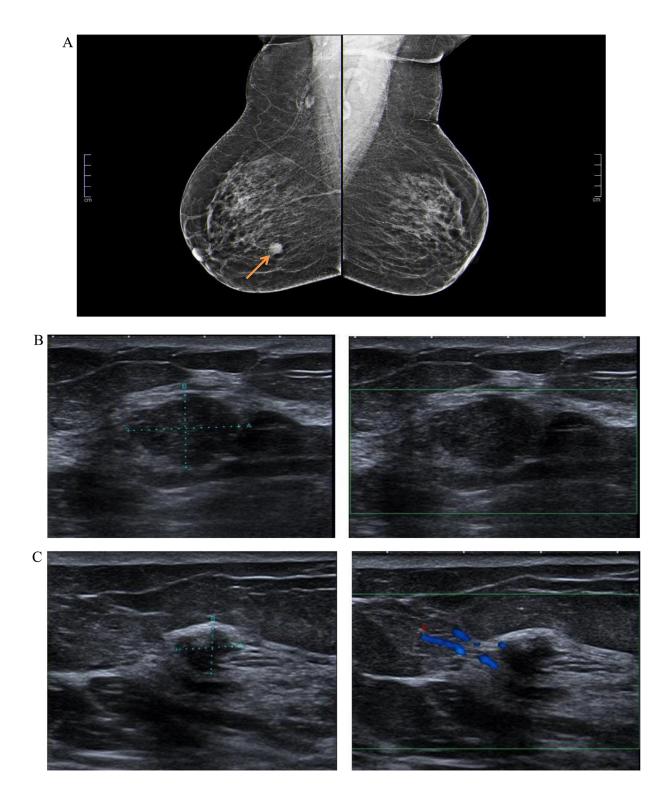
(A) Left and right breast mammograms: the left breast, does not reveal the suspicious lesion detected on ultrasonography; the right breast, clearly shows the mucinous cancer (arrow). (B) Right breast ultrasonogram: revealed a well-defined, round-shaped, heterogeneous, microlobulated hypoechoic solid-appearing lesion in the right breast at the 6 o'clock position. (C) Left breast ultrasonogram: revealed another suspicious lesion with irregular outline and posterior acoustic shadowing in the left breast at the 11 o'clock position.
